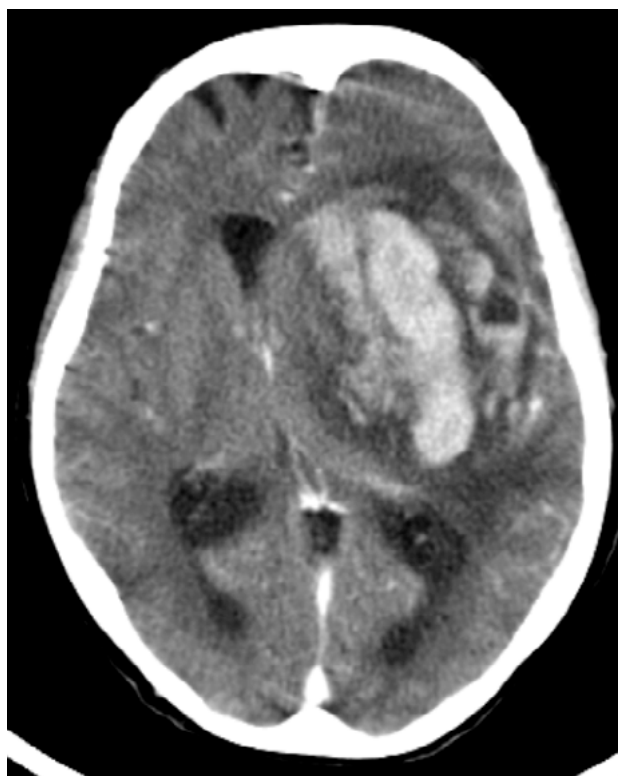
Cranioencephalic computed tomography – Rounded formations, compatible with abscesses, within massive left hemorrhagic lesion at the caudate-lenticulo-capsular level, with perilesional edema, compression of the ipsilateral ventricle, deviation of the midline structures, and a subfalcine and left transtentorial uncal herniation.
